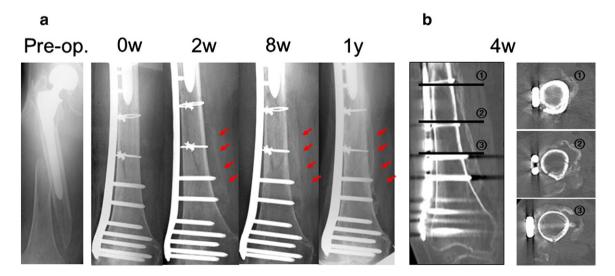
Case 2. A 96-year-old woman who sustained a periprosthetic femoral fracture of the right femur. (a) Anteroposterior radiograph of the right femur taken preoperatively, postoperatively, and 2 weeks, 8 weeks, and 1 year after initiation of teriparatide therapy. Obvious callus formation around the fracture site was observed at 2 and 8 weeks after treatment (arrow). After 1 year, remodeling of the fracture callus was complete (arrow). (b) CT scan of the right knee taken 4 weeks after initiation of teriparatide therapy.
